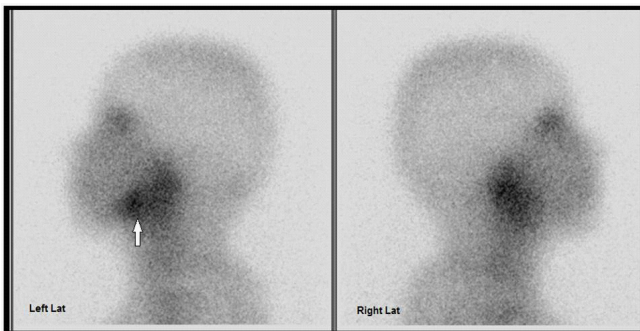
Planar (a) and SPECT CT (b) bone scan images showed enlarged and increased uptake in left condyle compared to right one consistent with left condylar hyperplasia (Arrows).
